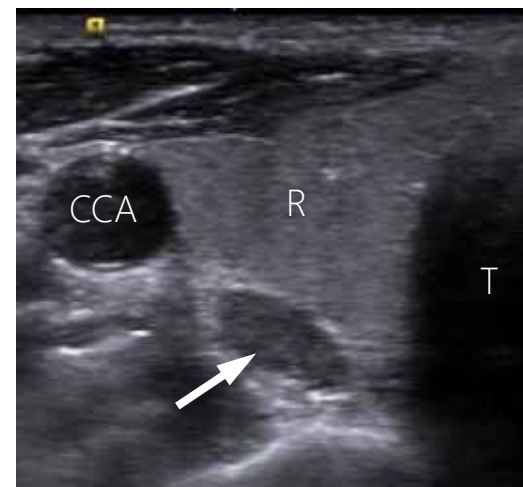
Ultrasonography (transverse image) shows a parathyroid adenoma (arrow) in a 36-year-old woman. Right lobe of the thyroid gland (R), right common carotid artery (CCA), trachea (T).
